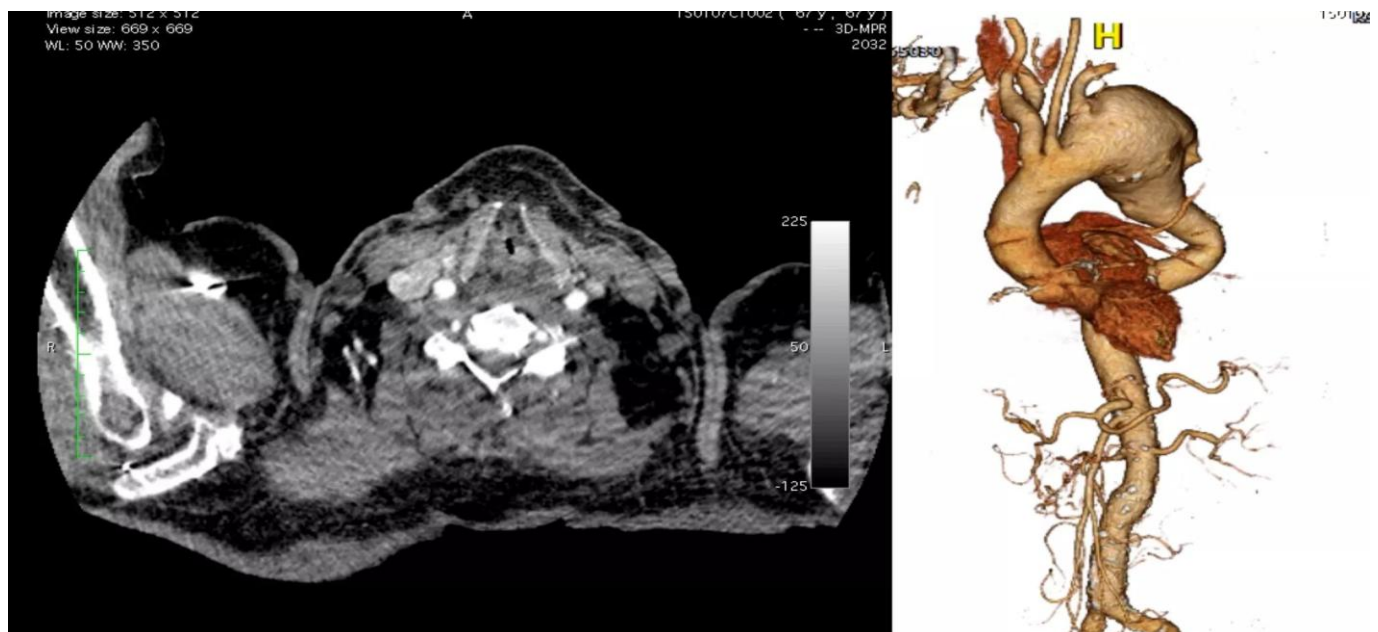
Imaging CT in Ascending & descending aorta
